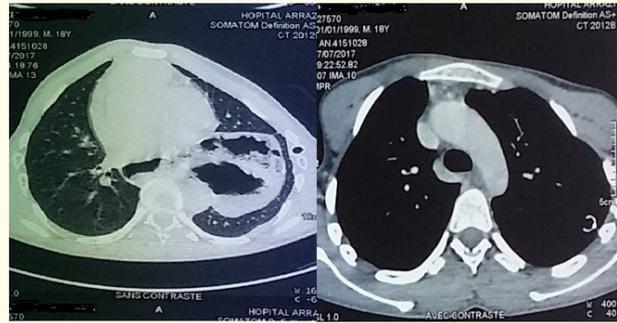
The chest computed tomography showed a small left pneumothorax, apical emphysema, an aneurysm of the aorta and a diaphragm hernia.
